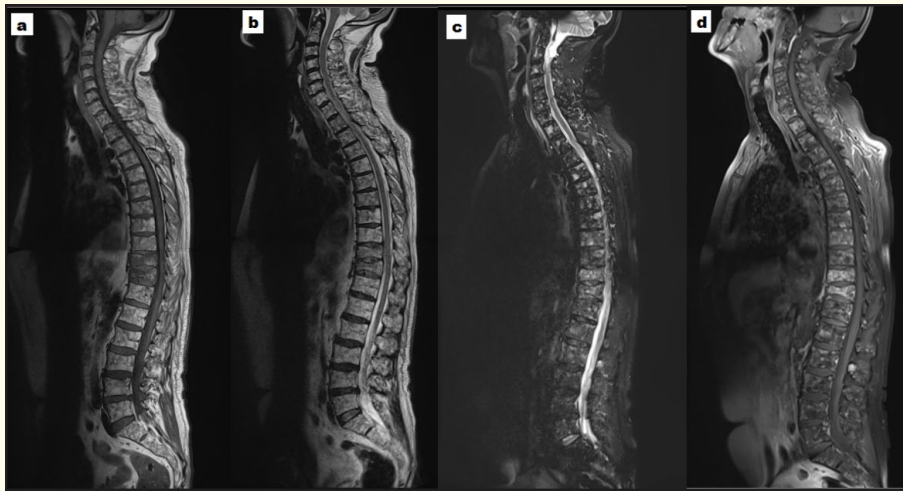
Sagittal MRI images, T1 sequence (a), T2 sequence (b), STIR sequence (c), and T1 post-Gadolinium injection (d), showing multiple nodular and micronodular signal abnormalities of the axial skeleton and thoracic cage with low signal on T1, high signal on T2 and STIR, and enhancement after Gadolinium injection. Severe biconcave compressions affecting the vertebral bodies of D10 and D11 are also observed, without signs of spinal cord or radicular compression.
